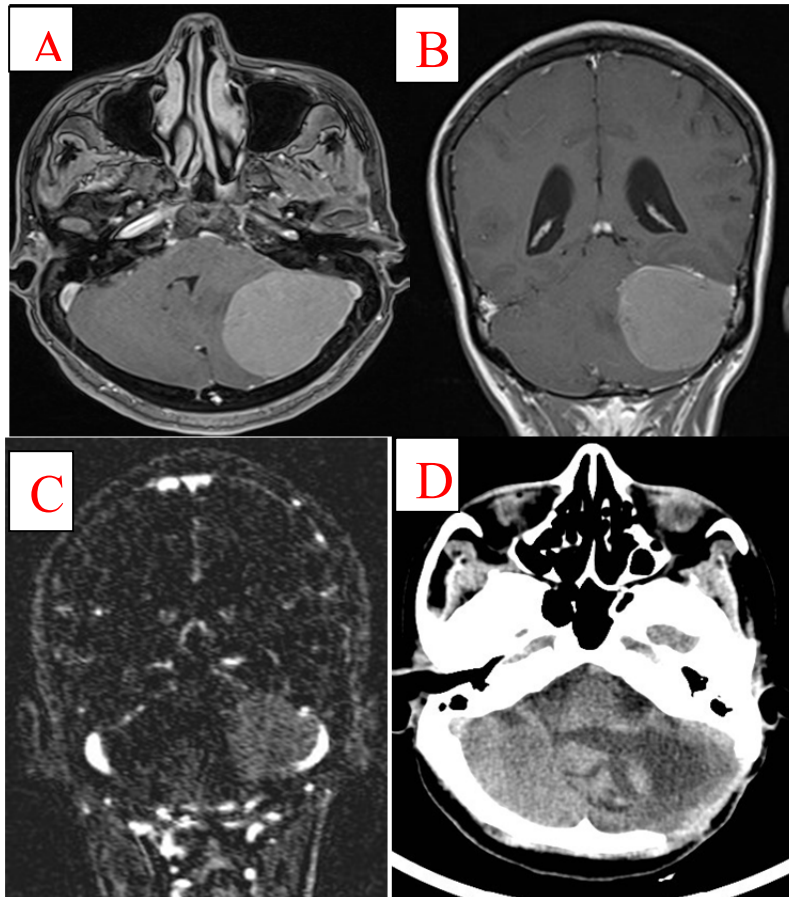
A and B showing axial and coronal contrast-MRI showing contrast-enhancing lesion, C. MRV showing compression and lateral displacement of left transverse sinus.D. Post-op CT-scan showing craniotomy defect which was approached through left RMSO approach.
